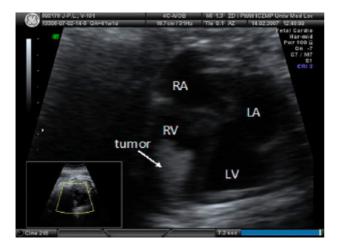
Echocardiographic image of fibroma
